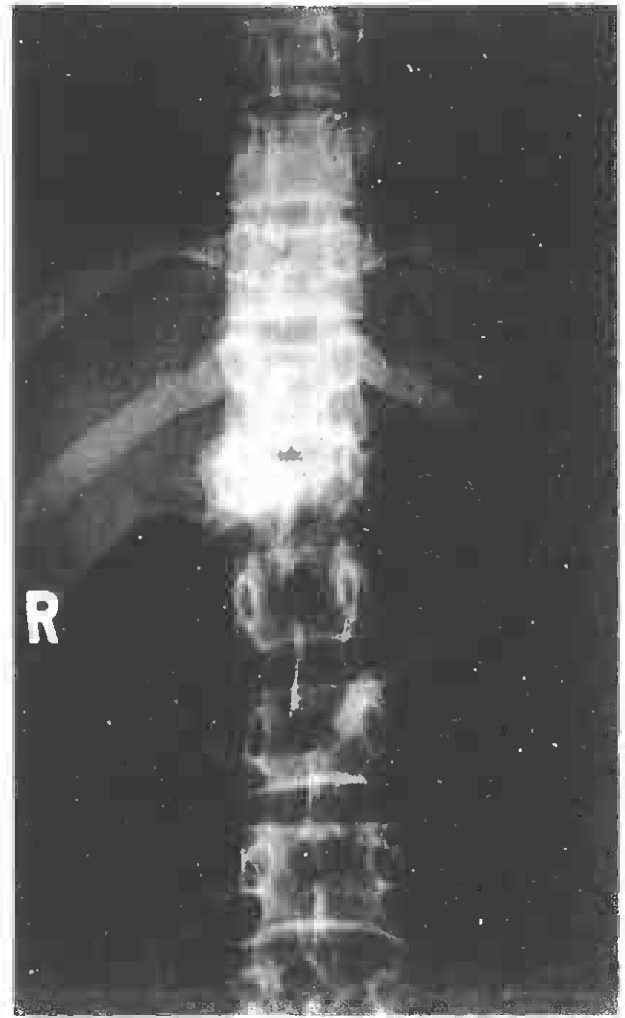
(a) Anteroposterior Radiographs of L.K.K.
